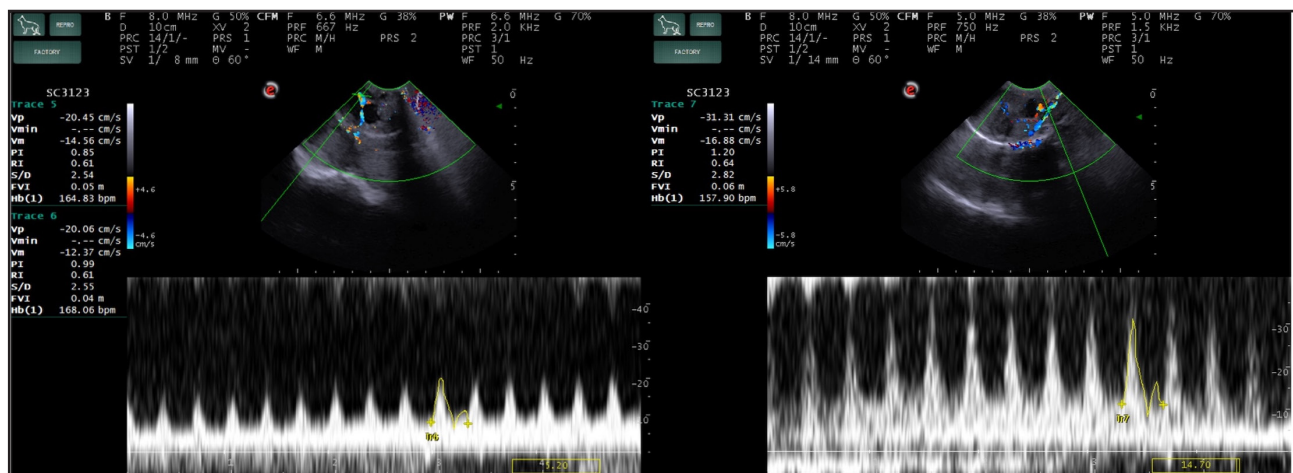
Color Doppler images of the primary mass in the cold group obtained Pre-T and Post-T solution infiltration, demonstrating changes in vascularization.
